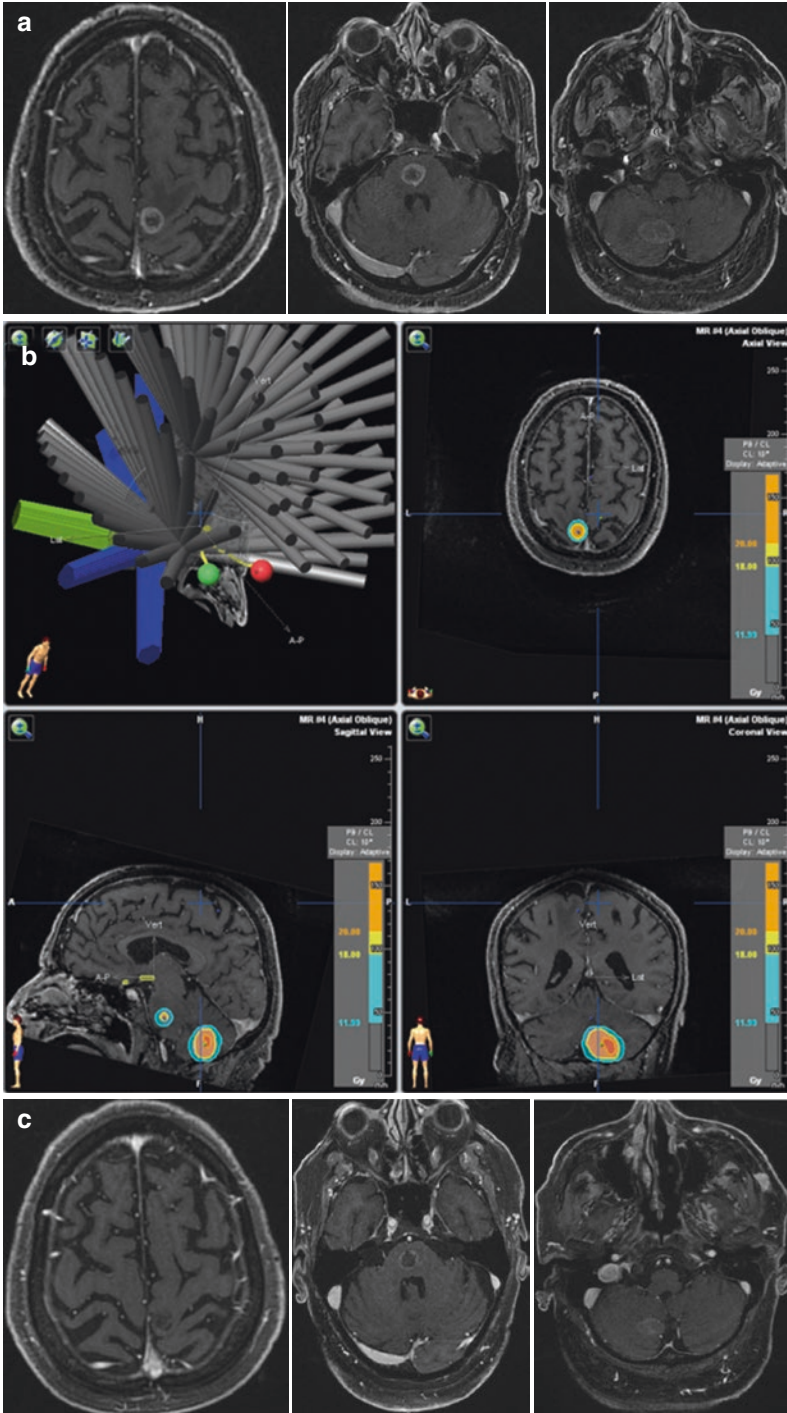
(a) Brain metastasis of colon cancer, MRI before SRS. (b) Treatment plan with SRS, Dose prescription 20 Gy periphery. (c) MRI 2 months follow up
